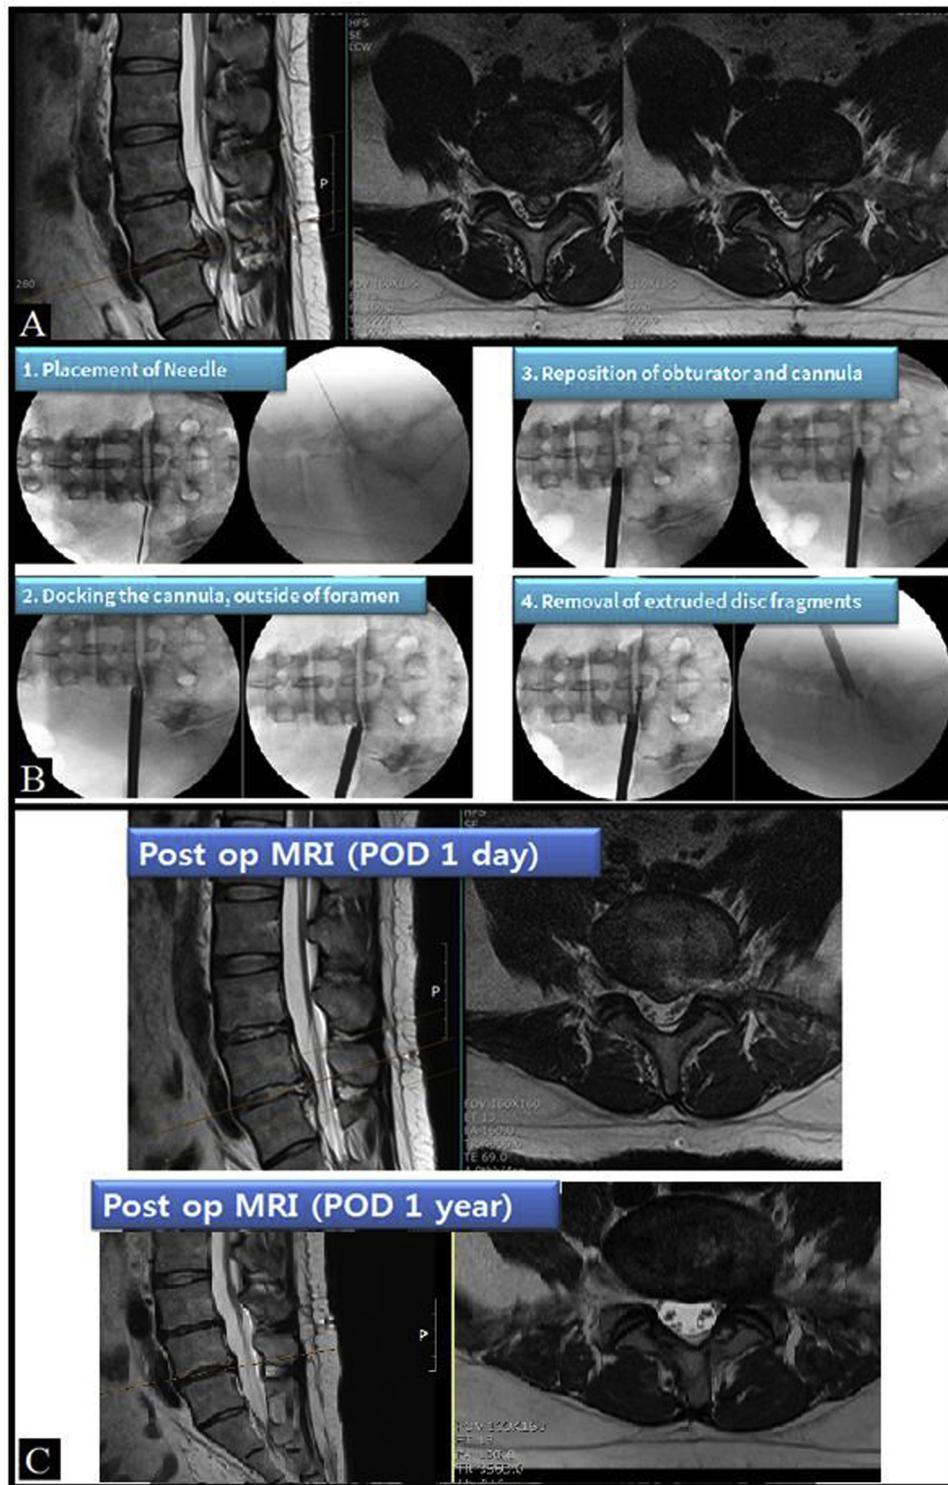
Case example. M/37, pain in both legs, left > right. A) Preoperative MRI showing huge central disc herniation at L4/L5 B) Intraoperative images C) Postoperative MRI at day 1 and at 1 year follow-up.
